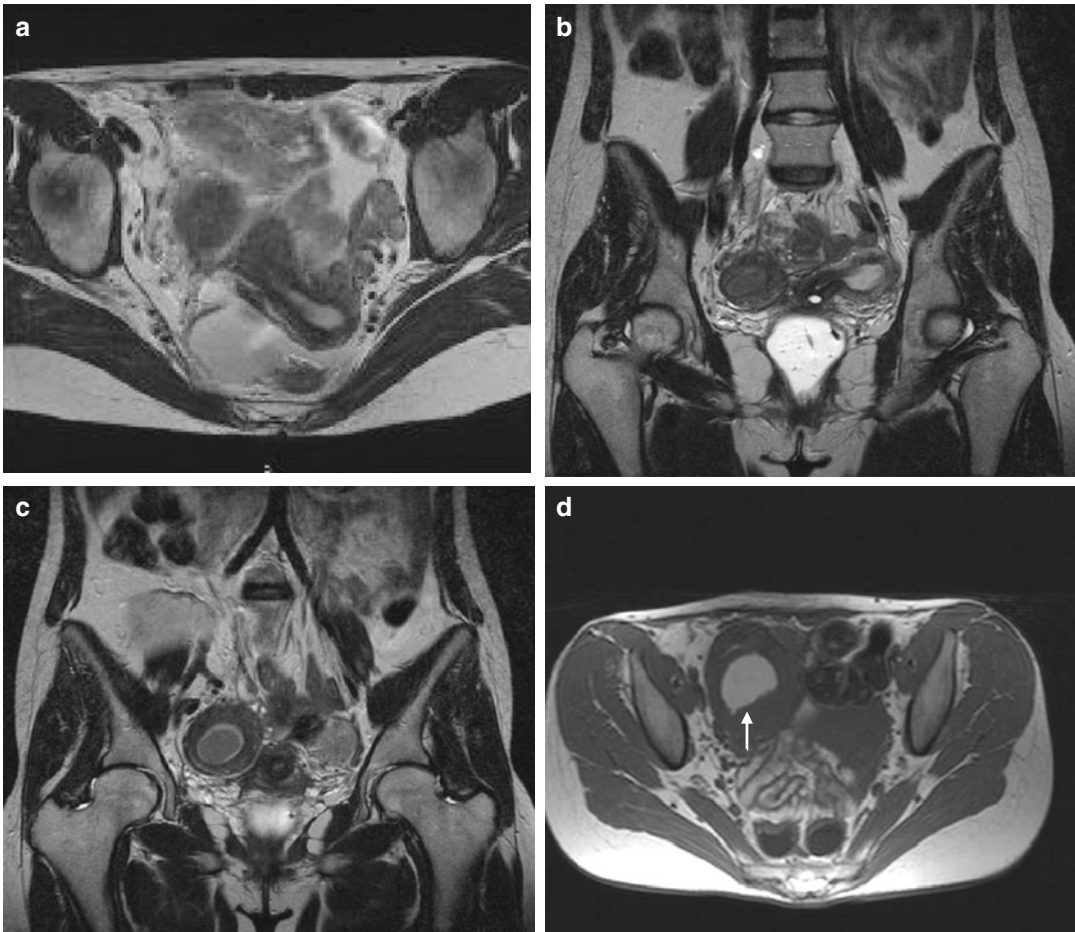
Non-communicating unicornuate uterus (II b). Fast spin-echo T2-weighted images on axial (TR/TE 3000/108) (a) and coronal plane (TR/TE 3310/94) (b, c); fast spin-echo T1-weighted images on axial (TR/TE 550/12) (d) show unicornuate uterus with non-communicating rudimentary horn that contains endometrium. No
